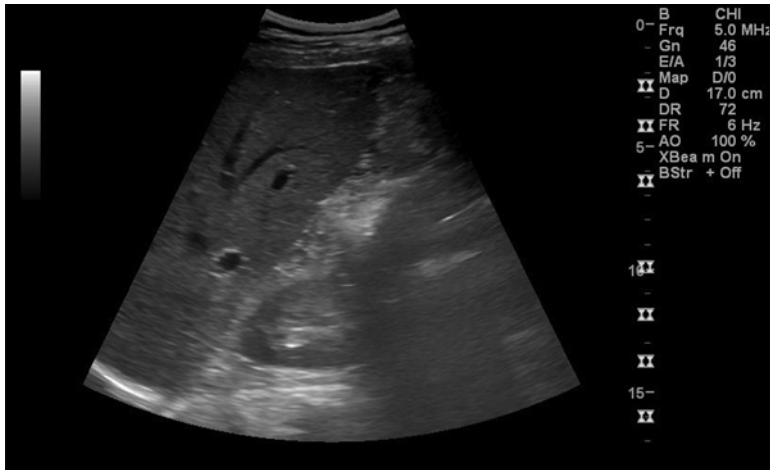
Showing ultrasound image obtained with multiple focal points
